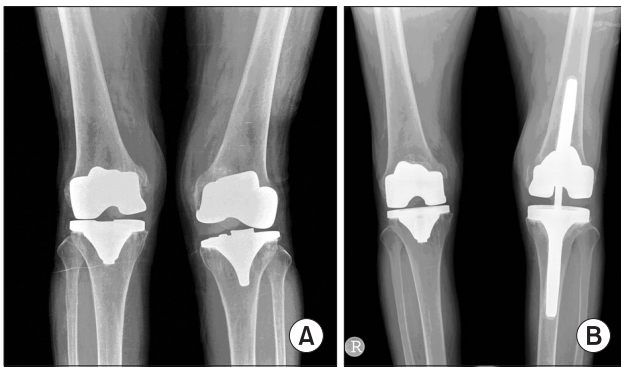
The left knee showed global instability on radiography and clinical examination (A). We performed a revision arthroplasty on the left knee with femoral and tibial component change (B).
